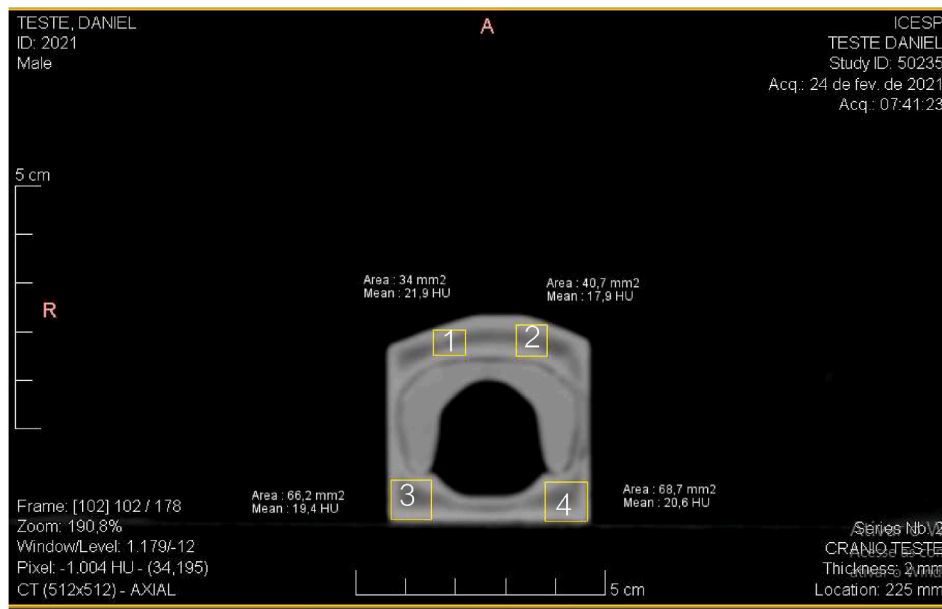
Investigation of CT numbers obtained for PLA in the thyroid accessory.
